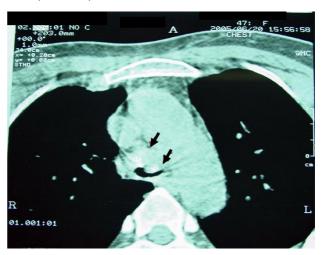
CT-scan of the same patient which shows the site of tumor (black arrows).
